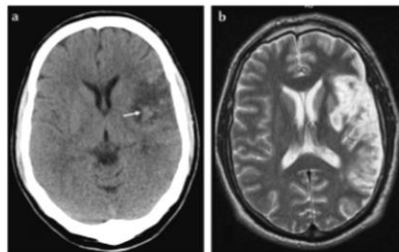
CT brain scan image (A) showing a large hypodense area in the left dorsolateral frontal (B) area due to cerebral infarction, with hyperintensities representing haemorrhagic changes in the centre (white arrow). The same is confirmed on a T2 axial MRI (B), which revealed slight posterior extension of the infarct.
